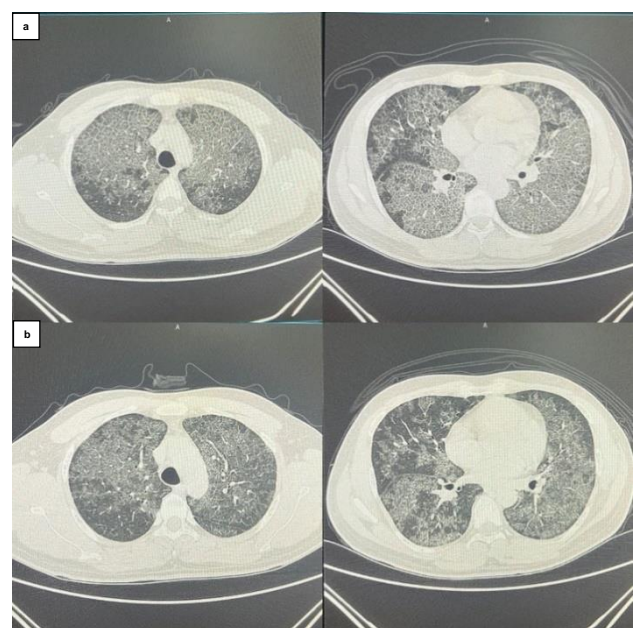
Axial view of thoracic computed tomography scan a) before and b) after granulocyte colony-stimulating factor (G-CSF) inhalation
